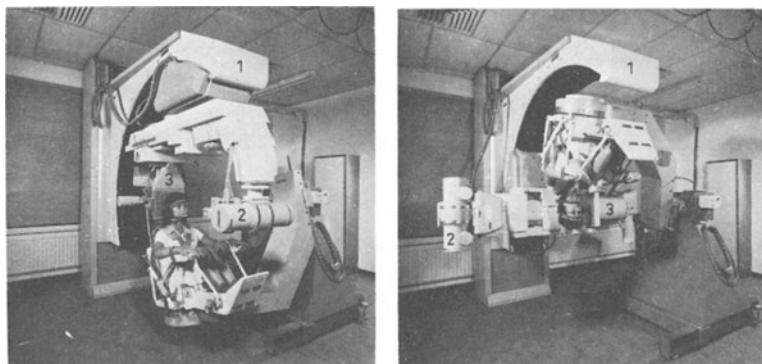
Stand for neuroradiological investigations with isocentric chair. 1. Stand as in figure 16.10. 2. X-ray tube; 3. image intensifier combination with cassette holder.
